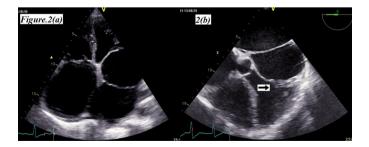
(a) Apical 4 chamber view of Transthoracic Echocardiogram (b) Trans Esophageal Echocardiogram showing the true and accessory atrial chambers with hypoplastic papillary muscle and short chordae (black arrow).
